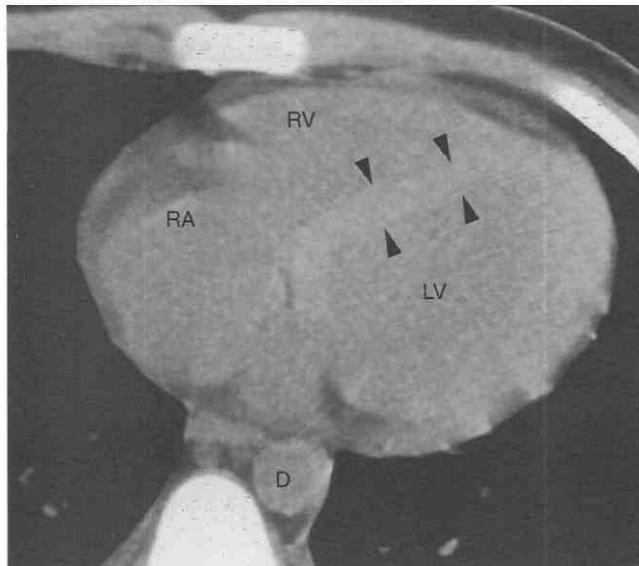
Anemia. Axial CT scan without contrast medium in an 18-year-old patient with a hematocrit of 23 mL/dL (normal range, 36 to 47 mL/dL). The interventricular septum (arrowheads) is visible because of the reduced density of the blood in the ventricles. D, descending aorta; LV, left ventricle; RA, right atrium; RV, right ventricle.
